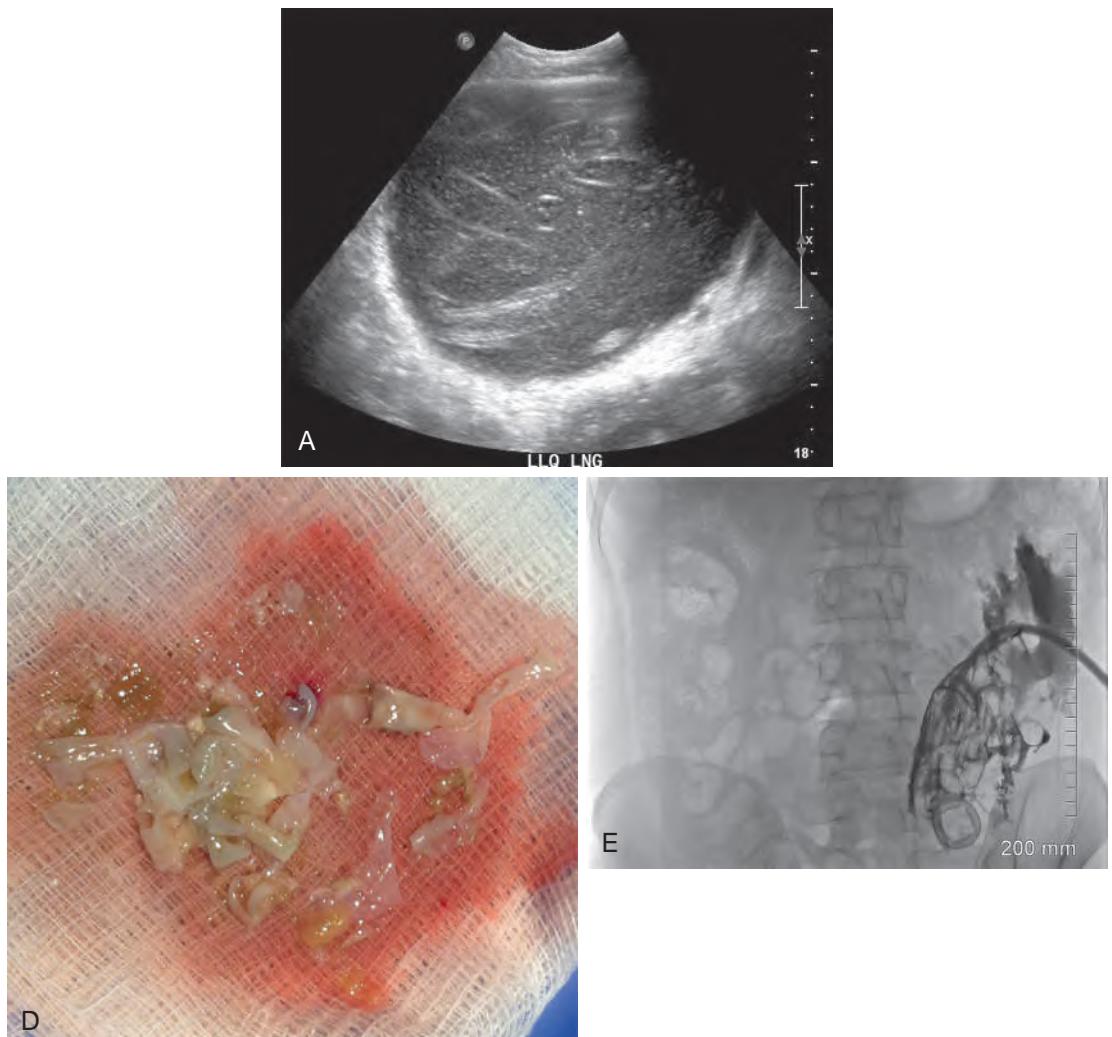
Hydatid cyst disease in a 26-year-old man who immigrated to the United States 11 years ago from Ethiopia. He presented to the outpatient medicine clinic with complaints of left back swelling and mild pain for 7 days. Axial (B) and coronal (C) images from a contrast-enhanced computed tomography (CT) scan demonstrates the  $27 \times 16 \times 25$  cm (a) well-circumscribed fluid collection in the left abdomen and extending to the left flank. Also shown on the coronal (C) CT image are the  $8 \times 6$  cm (b) collection with irregular calcifications in the right hepatic lobe and the subdiaphragmatic  $9 \times 7$  cm (c) collection in the hepatic dome.
